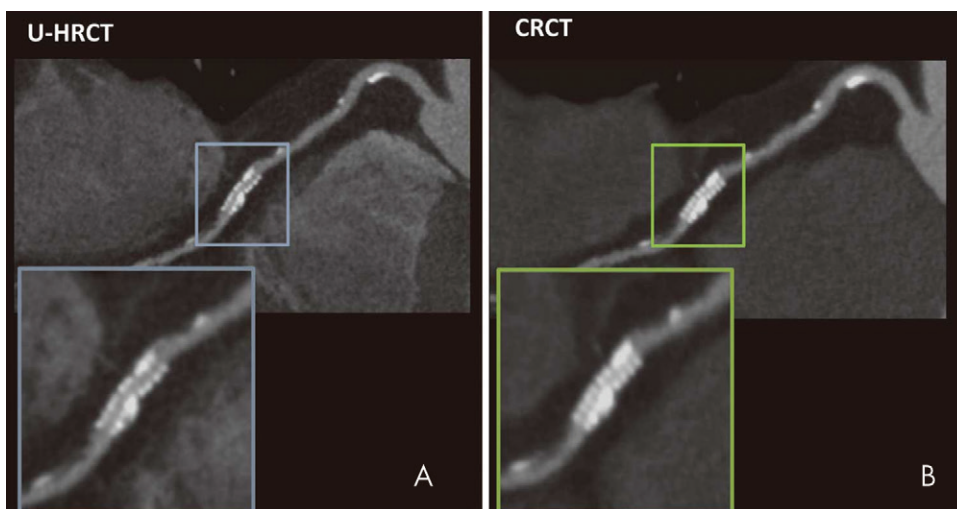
In vivo CT image shows a 2.5-mm stent depicted with, A, ultra-high-resolution CT (U-HRCT) (0.18-mm resolution) and, B, conventional-resolution CT (CRCT) (0.35-mm resolution). (Reprinted, with permission, from reference 30.)
